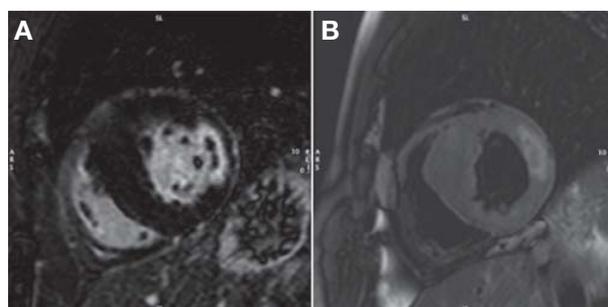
A) Lateral wall LGE with MVO. B) T2-weighted image showing edematous region with dark core in area of MVO, suggesting intramyocardial hemorrhage.
